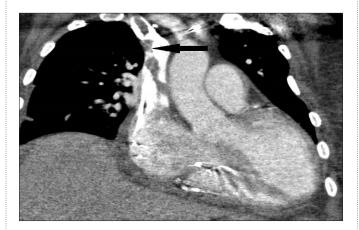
CT scan of the thorax shows thrombus extending from right internal jugular vein to the brachiocephalic vein and the superior vena cava at the cavoatrial junction (arrow).
